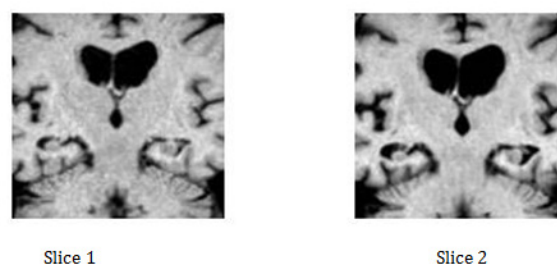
Serial MRI, Adding the time dimension, time-interval between slice 1 and slice 2 is 2 years.
